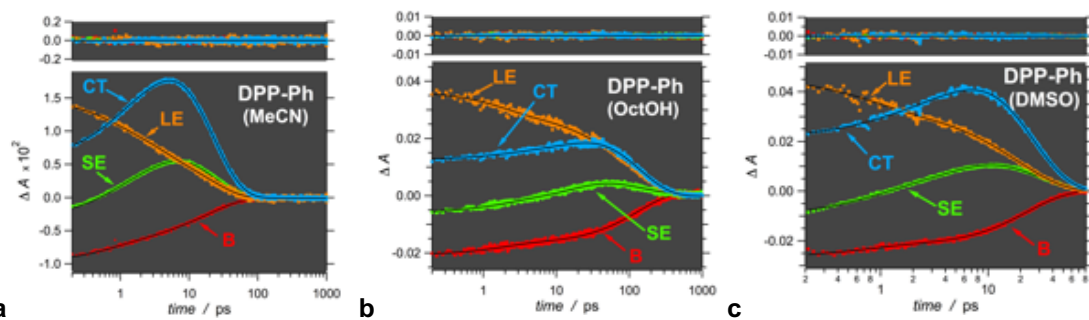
Global fits (eq. S2) using three exponential terms for four wavelengths: 770 nm (LE), 640 nm (CT), 550 nm (SE) and 500 nm (B). The data points are colored differently for the different wavelengths as labeled. The solid black lines represent the fitting functions obtained from the least-squares regression analysis for each solvent. The upper section of each graph shows the residuals from the global fits.
